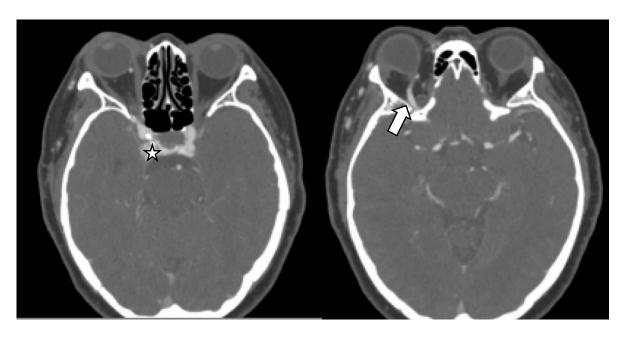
CT-angiography revealed engorgement on the right cavernous sinus (star) and superior ophthalmic vein (SOV) dilatation (arrow) that suggest carotid-cavernous fistula (CCF).
